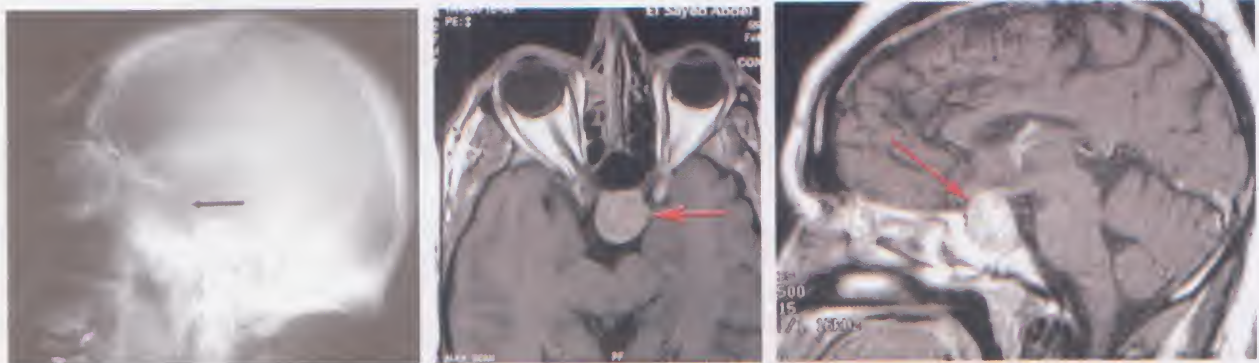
Plain x-ray skull (left), lateral view showing expanded sella turcica. Axial and sagittal MRI images of the sella turcica showing a pituitary adenoma
